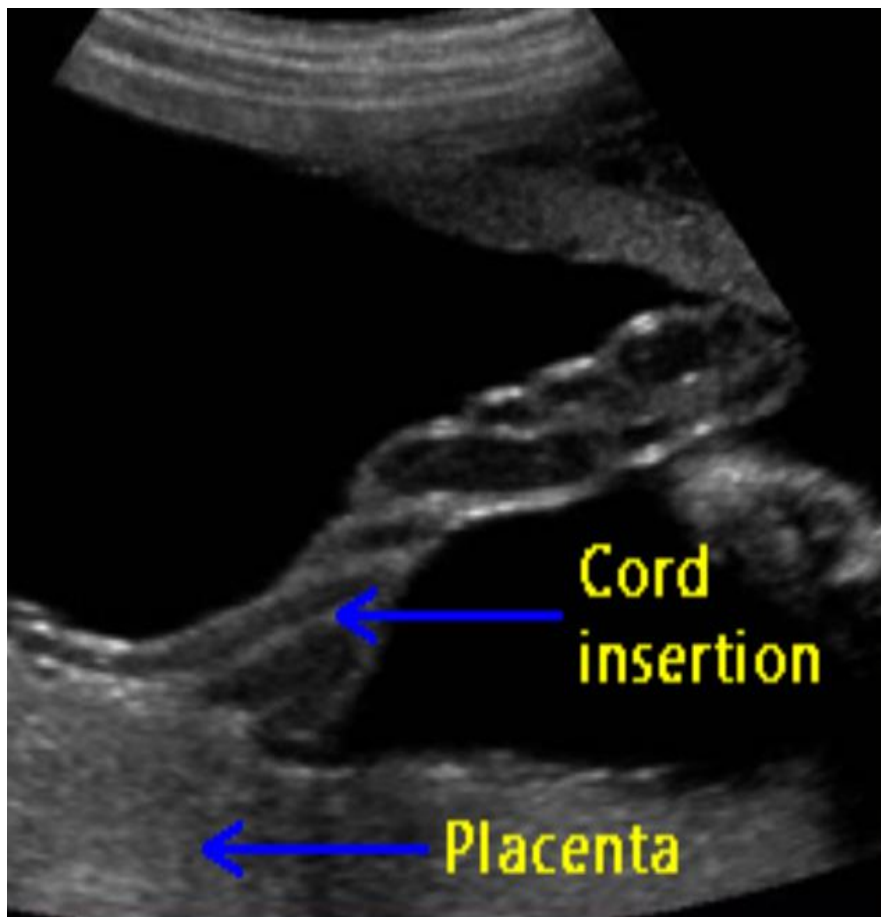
Sonographic appearance of a normal umbilical cord & placenta, transeabdominal scan.(<https://www.obimages.net>; 2018)
